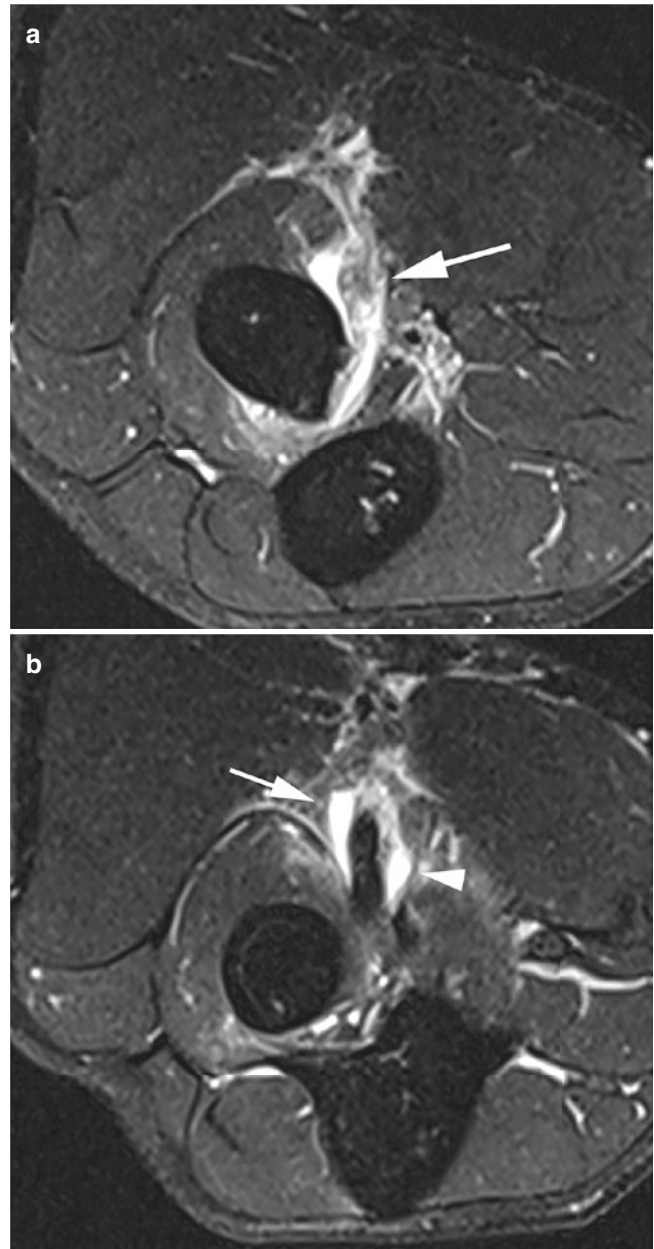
Biceps tendon tear. (a) Axial fat-saturated T2-weighted image shows near complete tearing of the biceps tendon from the radial tuberosity (arrow). A more proximal image (b) demonstrates some associated distention of the radiobicipital bursa (arrow) and interosseous bursa (arrowhead)
